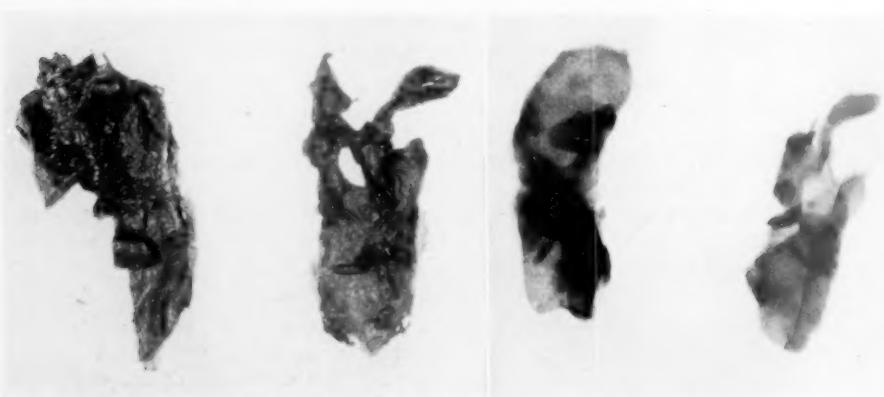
Photograph on the left and X-ray on right of part of synovial membrane removed at operation. The dense shadow cast by this tissue in the X-ray is due to the large amount of iron in it.
